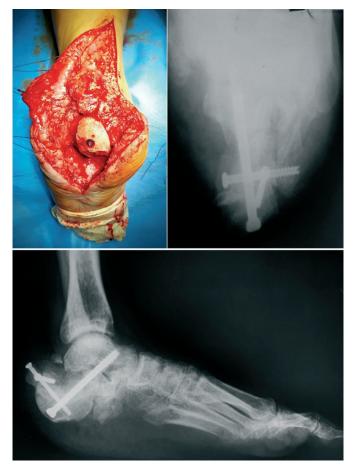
Case 1. View of the surgical field and X-ray of the foot after surgery.
